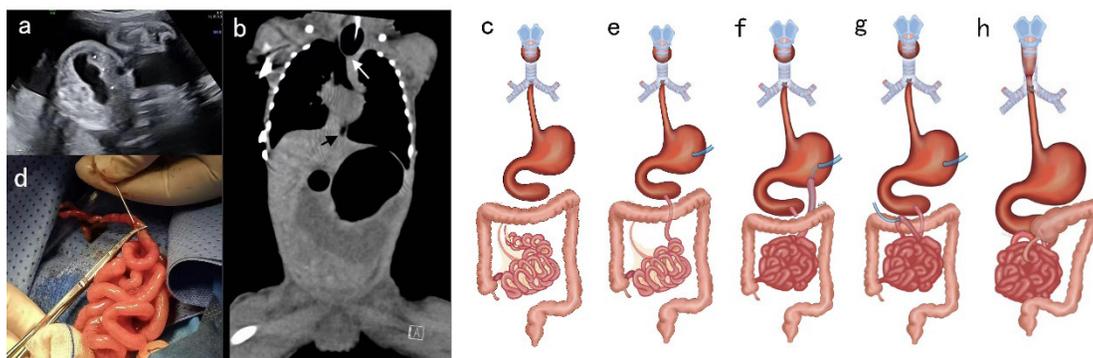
(a)Prenatal ultrasound indicates a linear cystic mass in the abdominal cavity; (b)Chest CT shows proximal esophageal atresia at approximately T2 (white arrow), distal esophagus visible (black arrow), and double bubble sign in the abdomen, indicating duodenal atresia; (c) Sketch of long segment esophageal atresia, duodenal atresia, and intestinal atresia of the patient; (d)The image of intestinal atresia;(e-h) Surgical sketch map.
